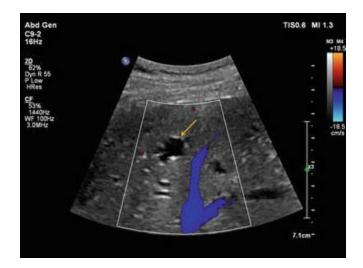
Same patient as in Fig. 6. Color Doppler confirms the diagnosis of the native B-mode ultrasound with no detectable blood flow inside the cyst (*yellow arrow*)
